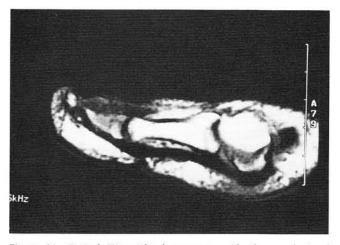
Sagittal T1-weighted sequence with decreased signal intensity.
